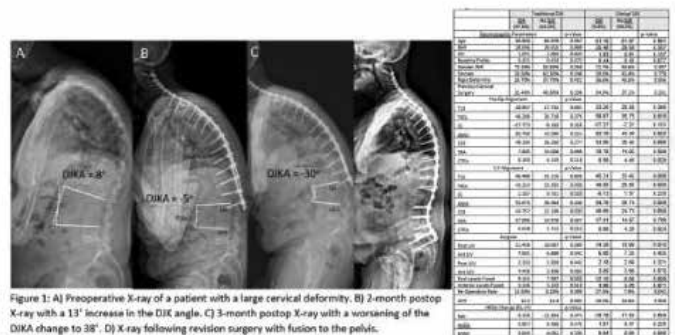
A) Preoperative X-ray of a patient with a large cervical deformity. B) 2-month postop X-ray with a 13° increase in the DJK angle. C) 3-month postop X-ray with a worsening of the DJKA change to 35°. D) X-ray following revision surgery with fusion to the pelvis.
